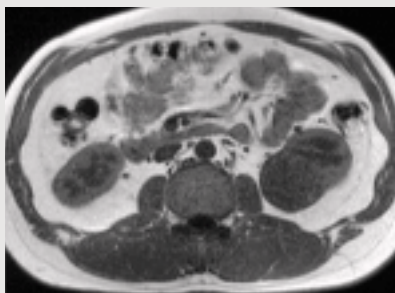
T1-weighted image
